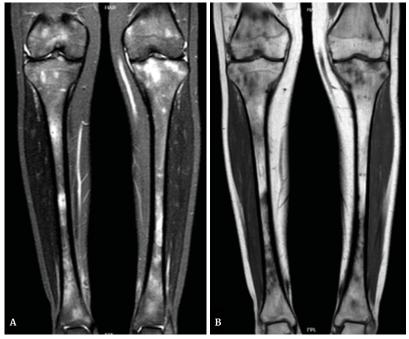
Comparative nuclear MRI of the legs. A) STIR sequence; B) T1 weighted image. Source: Document obtained during the study.
